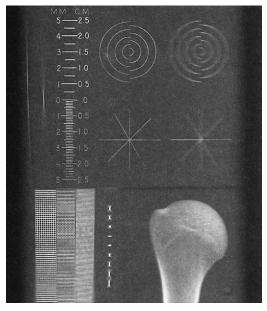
This test object image shows properly calibrated elevation and increased blur of objects perpendicular to the motion of the x-ray tube. (Courtesy Sharon Glaze, Baylor College of Medicine.)
